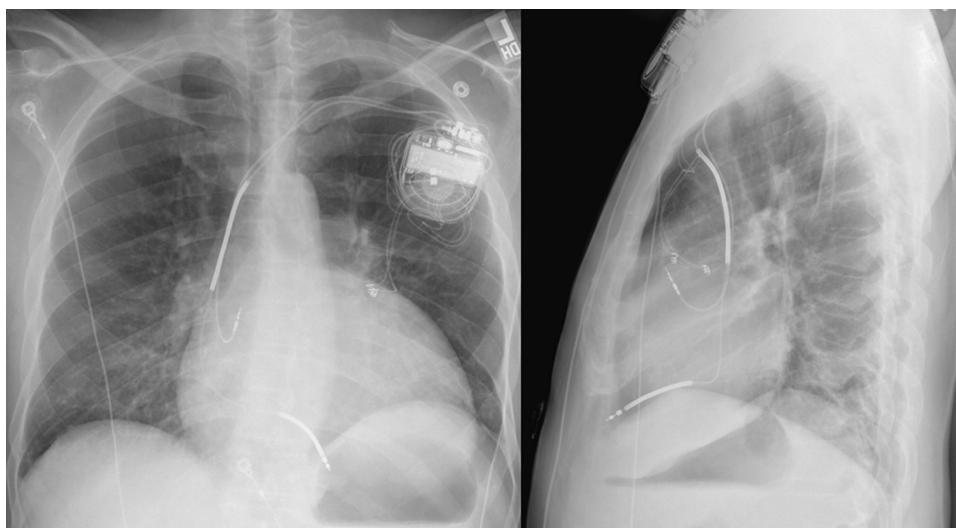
Posteroanterior and lateral chest radiograph demonstrating the position of the 2 left ventricular epicardial leads.
